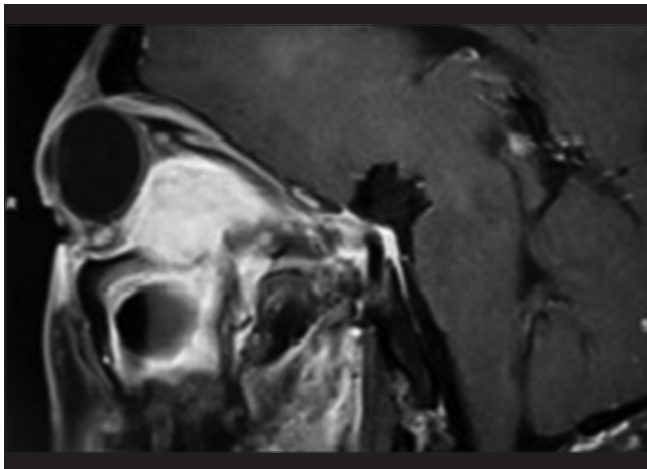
Contrast-enhanced T1-weighted magnetic resonance imaging of sagittal view showed right retrobulbar mass extended to orbital apex with erosion of the orbital floor
